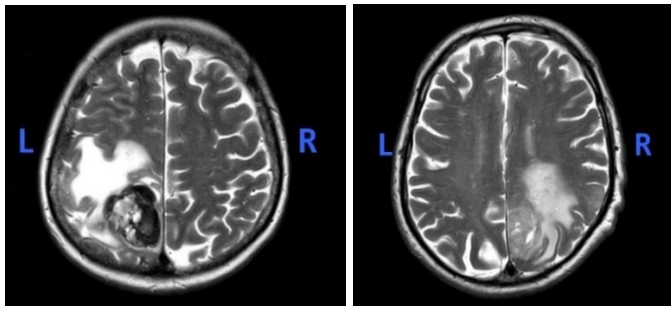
T2-weighted MR images of PO-LH (left side) and PO-RH (right side)
